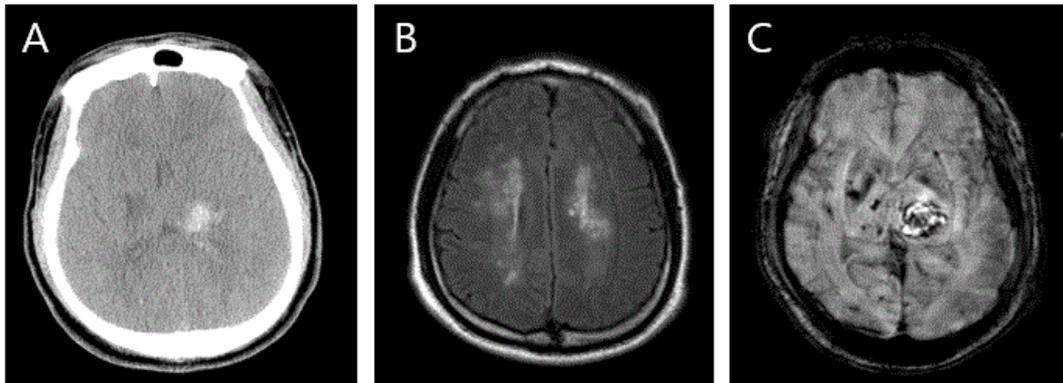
CT and MRI findings in CADASIL patient (A) CT scan shows intracerebral hemorrhage in left thalamus (B) MRI (T2 weighted image) shows chronic ischemic change and leukomalacia in both periventricular white matter (C) MRI (Susceptibility Weighted Image) shows several microbleeds at both basal ganglia and thalamus
